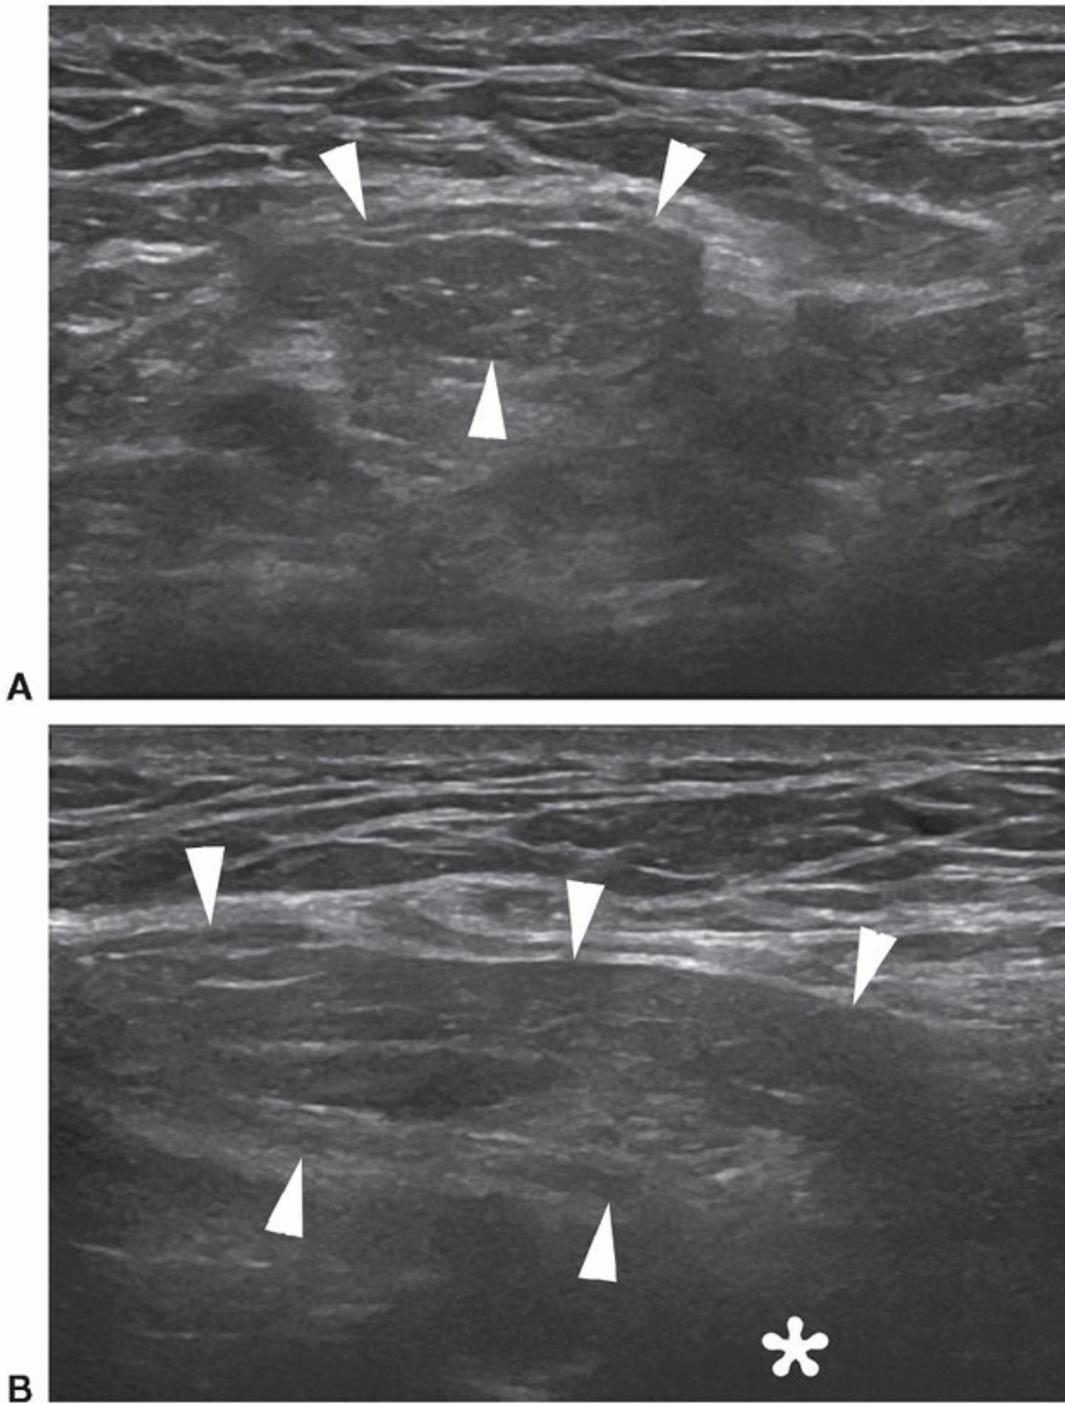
Indirect inguinal hernia. Sonograms of the inguinal canal. A: Short axis during Valsalva shows hernia containing fat (arrowheads) expanding the canal and effacing contents. B: Long axis during Valsalva shows hernia containing fat (arrowheads). The location of the inferior epigastric vessels is marked (asterisk) with the hernia arising laterally.
